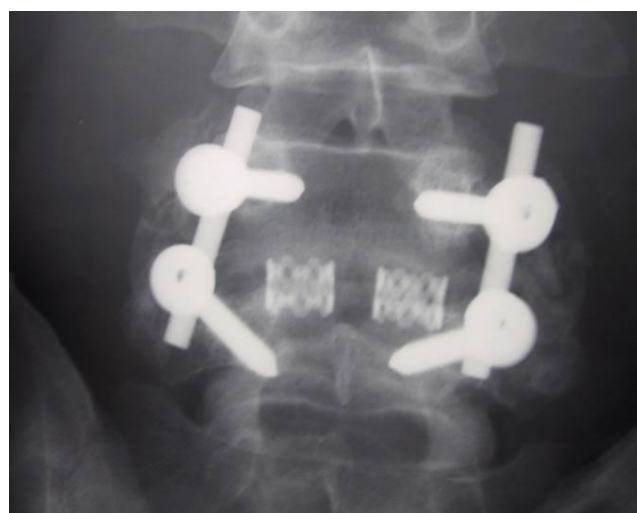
2 year follow-up lateral (a) and AP (b) radiographs showing solid fusion without progression of slippage at any level.
